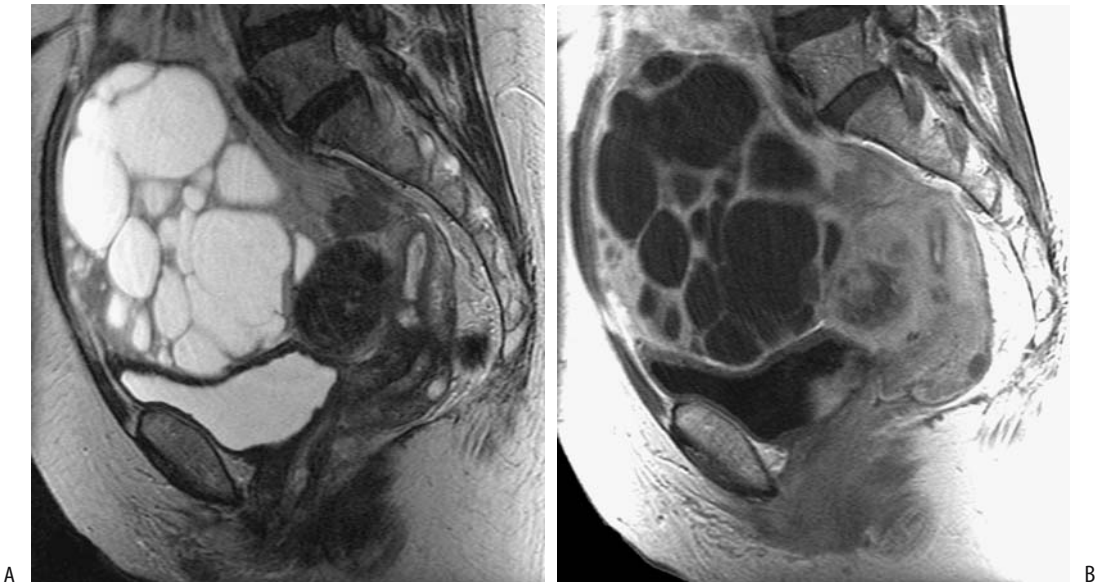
Granulosa cell tumor in a woman with bleeding and elevated estradiol level. A: Sagittal T2-weighted magnetic resonance (MR) identifies a multicystic tumor anterior to the uterus. The uterus is enlarged, has thickened endometrium, and contains a leiomyoma. B: Sagittal post-contrast T1-weighted image reveals enhancing tumor wall and septa. (Source: Kido A, Togashi K, Koyama T, Yamaoka T, Fujiwara T, Fujii S. Diffusely enlarged uterus: evaluation with MR imaging. *RadioGraphics* 2003;23:1423–1439, with permission from the Radiological Society of North America.)
